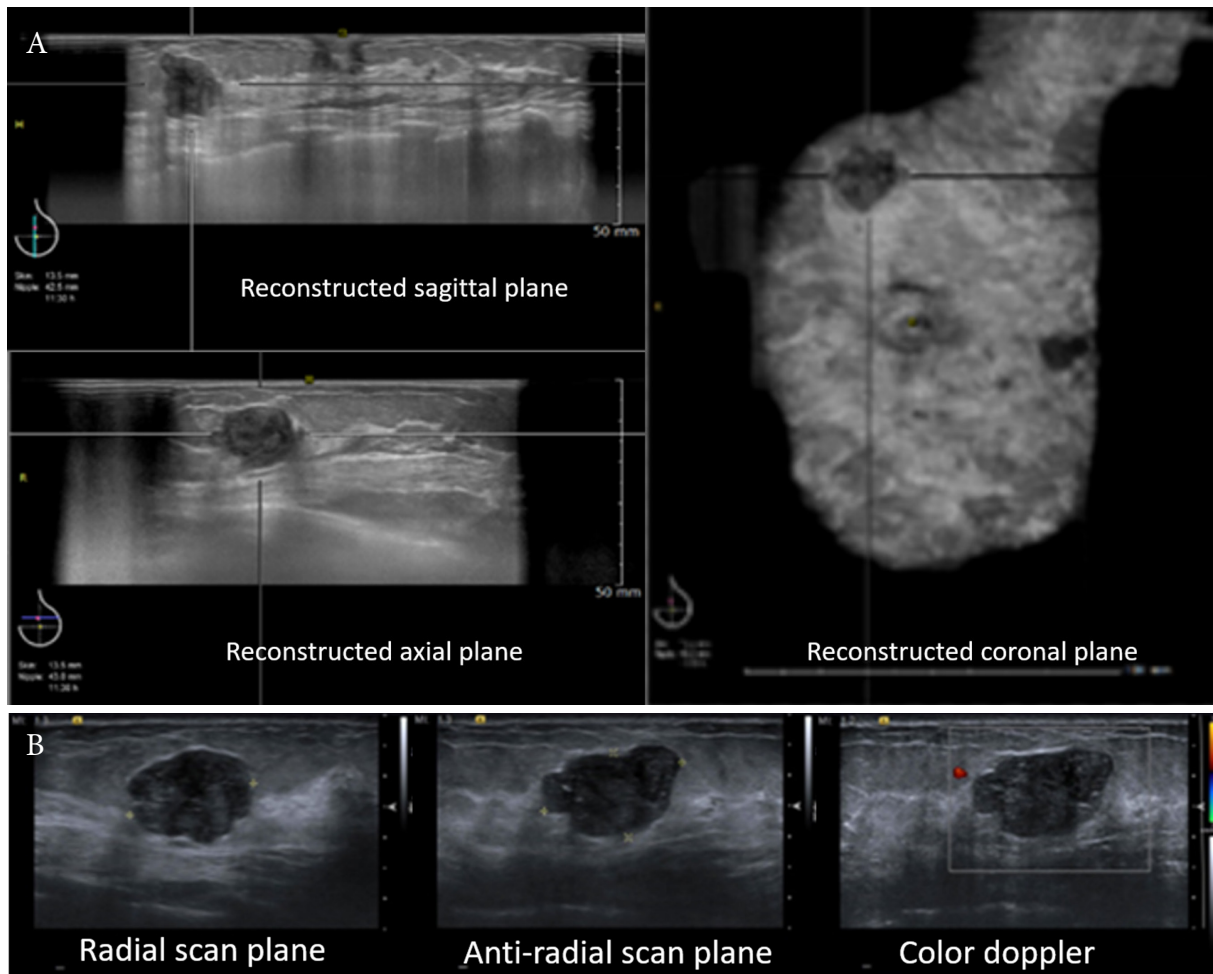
Ultrasound findings in ABUS (A) and HHUS (B) showed an oval, microlobulated, heterogeneous hypoechoic mass with parallel orientation and enhancement of the posterior feature at 11-12 o'clock of the left breast. There was no vascularity. (BI-RADS IVa) The pathologic result was fibroadenoma at the left breast.*
